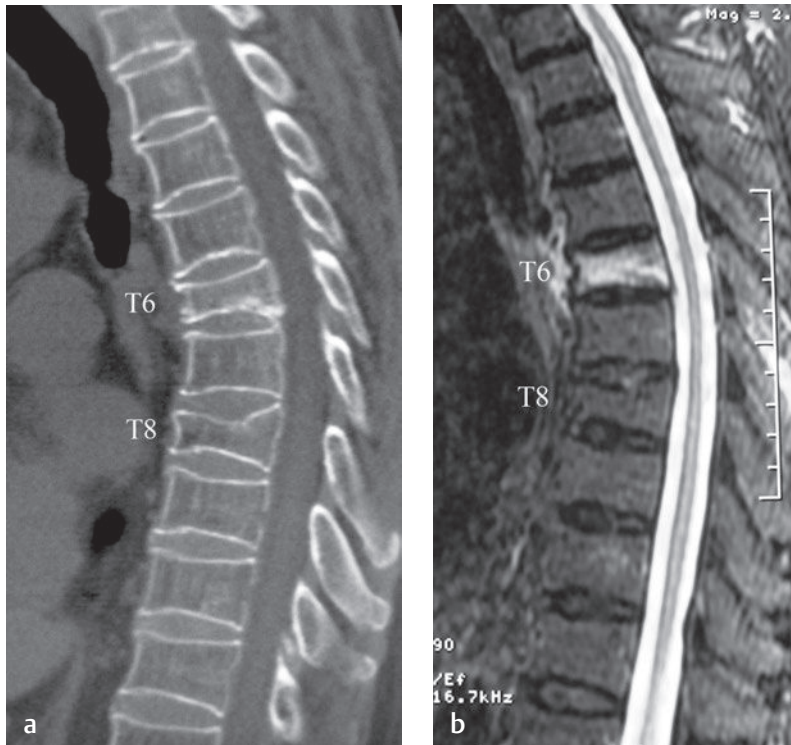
Vertebral compression fracture. (a) A sagittal reconstructed CT image shows vertebral compression fractures at the T6 and T8 levels. (b) A sagittal STIR image shows that the T6 vertebral compression fracture has increased signal compatible with edema within it, which is representative of an acute or subacute fracture. The T8 vertebral compression fracture shows no increase in signal within it, which is compatible with a chronic vertebral compression fracture.[†]
